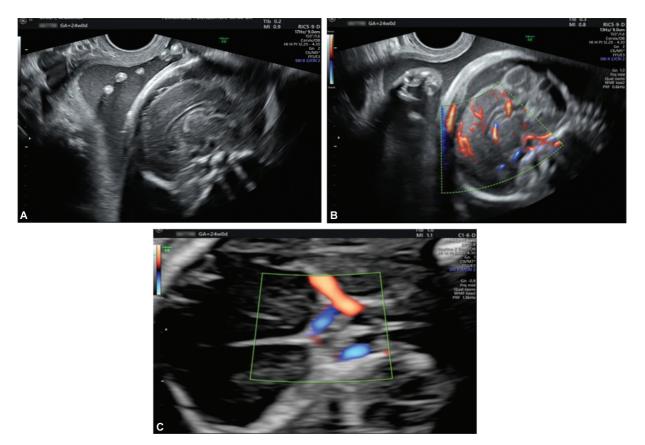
(A) Sagittal view showing corpus callosum. (B) Color doppler showing corpus callosum. (C) This part demonstrating optic tracts.
